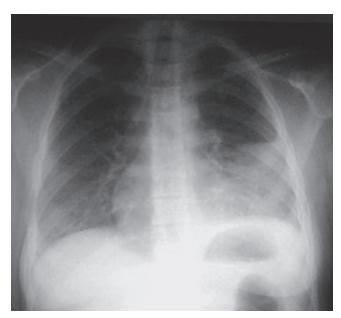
Plain radiograph showing left lower lobe pneumonia and a parapneumonic effusion, typical of acute bacterial pneumonia.
